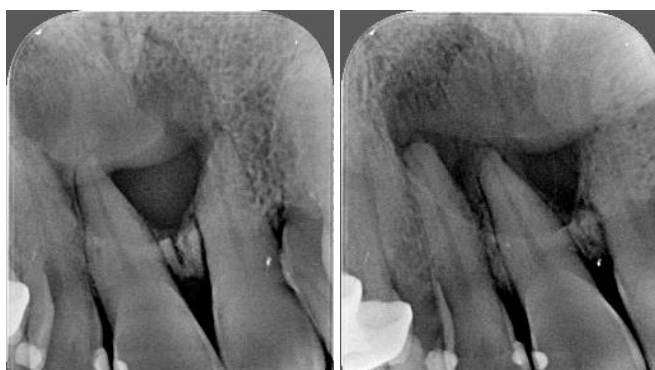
Retroalveolar intraoral dental X-ray
